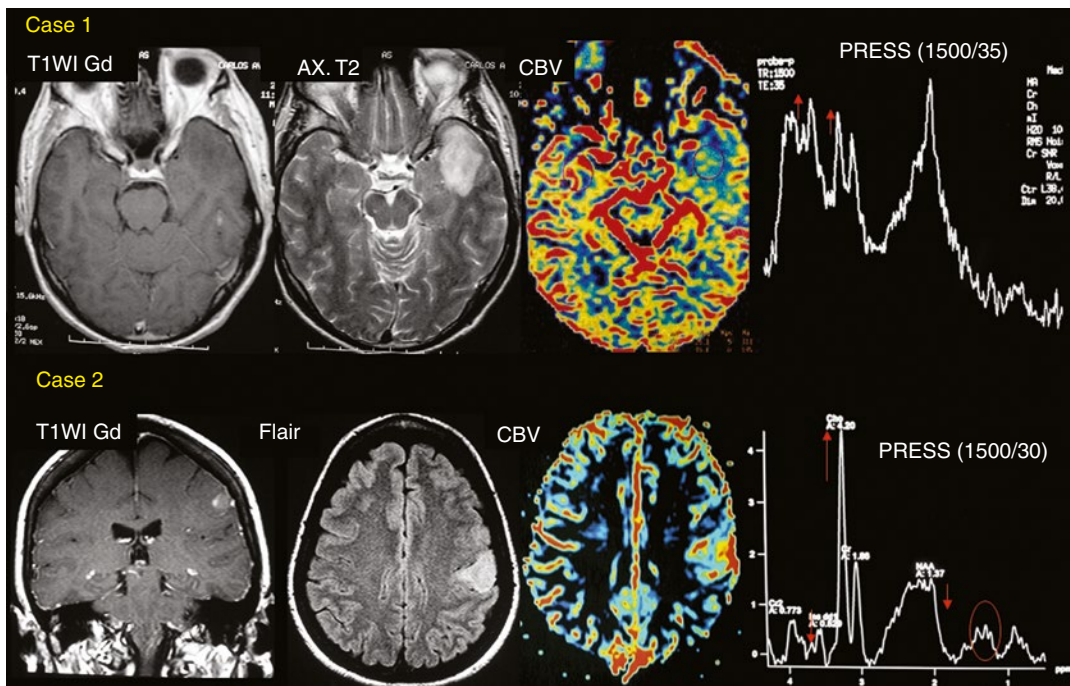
Case 1. A 51-year-old man with a diagnosis of low-grade glioma presented with seizures and headache. The lesion does not enhance after contrast administration and MRS demonstrates elevation of choline and myoinositol and a reduction of NAA. Low rCBV on DSC-MRI suggests a low-grade glial tumor. Case 2. A 51-year-old
